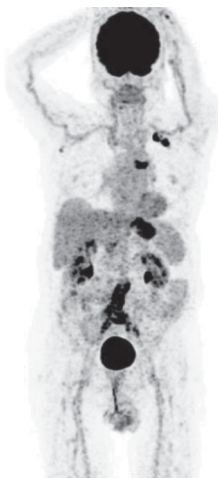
Multiple intensity projection image of F-18 FDG PET/CT demonstrates the large vessel uptake and additional FDG accumulation in lung lesions
